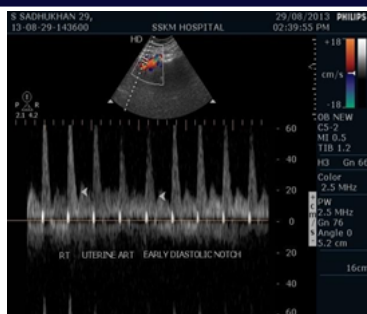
Doppler Waveform of Right Uterine Artery showing Diastolic Notch in second trimester
